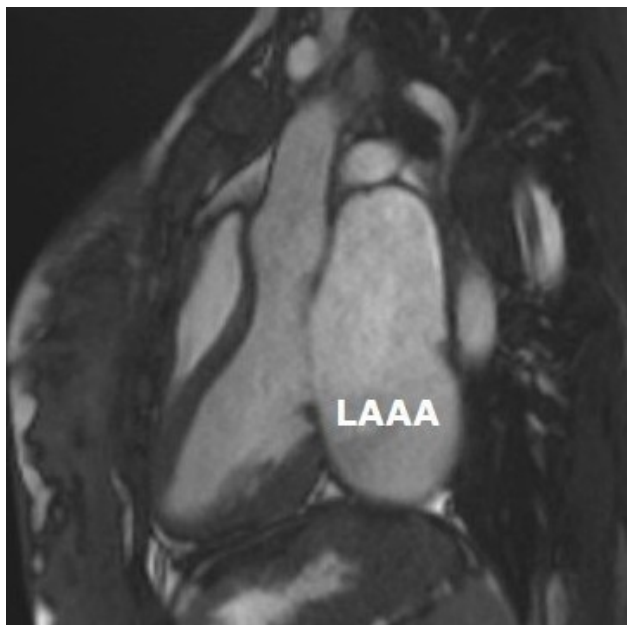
Cardiac MRI. Sagittal 3-chamber view from cardiac MRI showing a giant left atrial appendage dilatation. LAAA, Left atrial appendage aneurysm. MRI, Magnetic Resonance Imaging.
